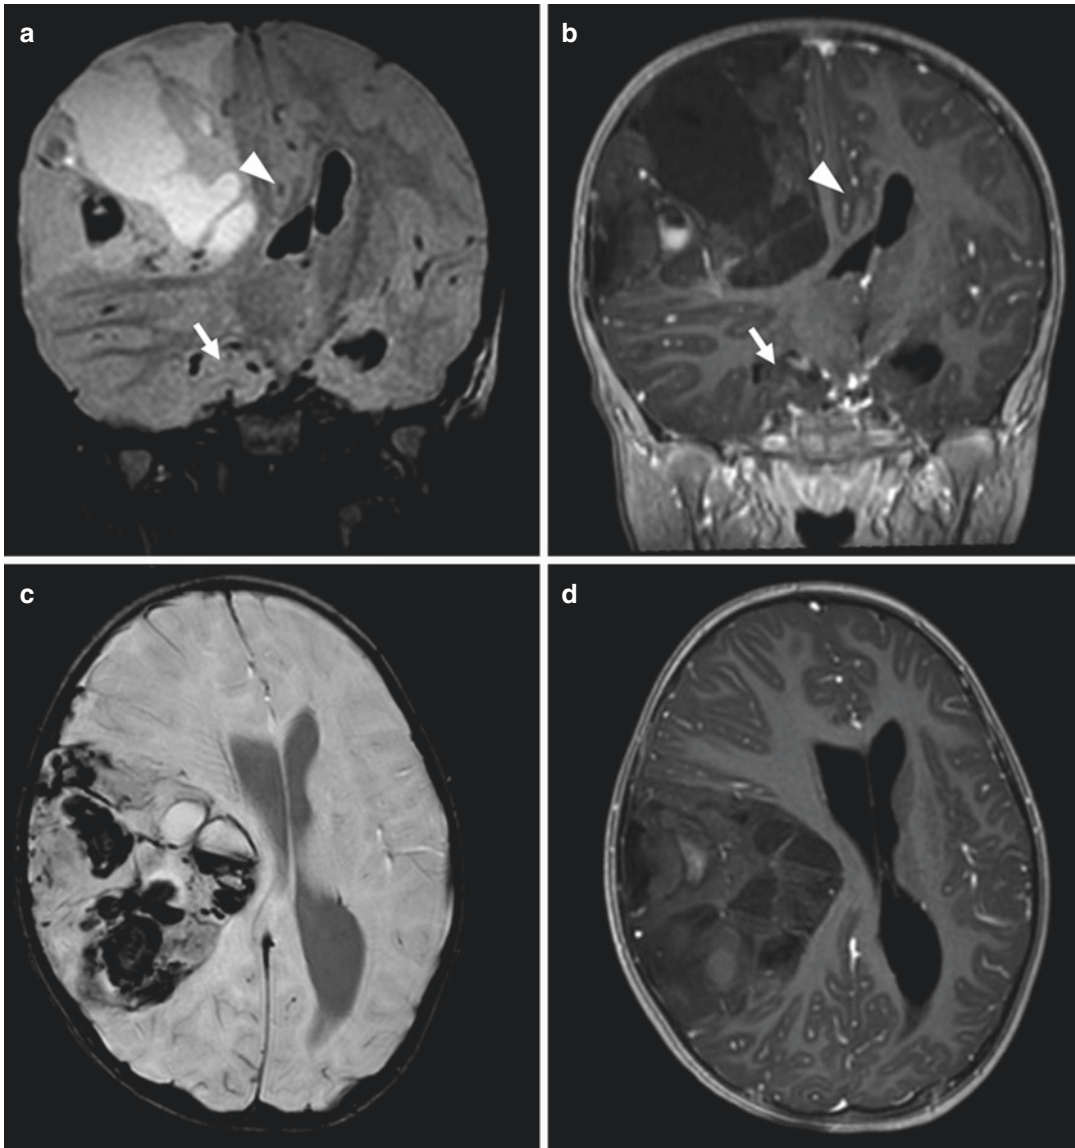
Intratumoral hemorrhage. Massive hemispheric desmoplastic infantile ganglioglioma with intratumoral hemorrhage, which intensifies the mass effect: Coronal FLAIR-weighted (a) and gadolinium-enhanced T1-weighted images (b) show incipient subfalcine
